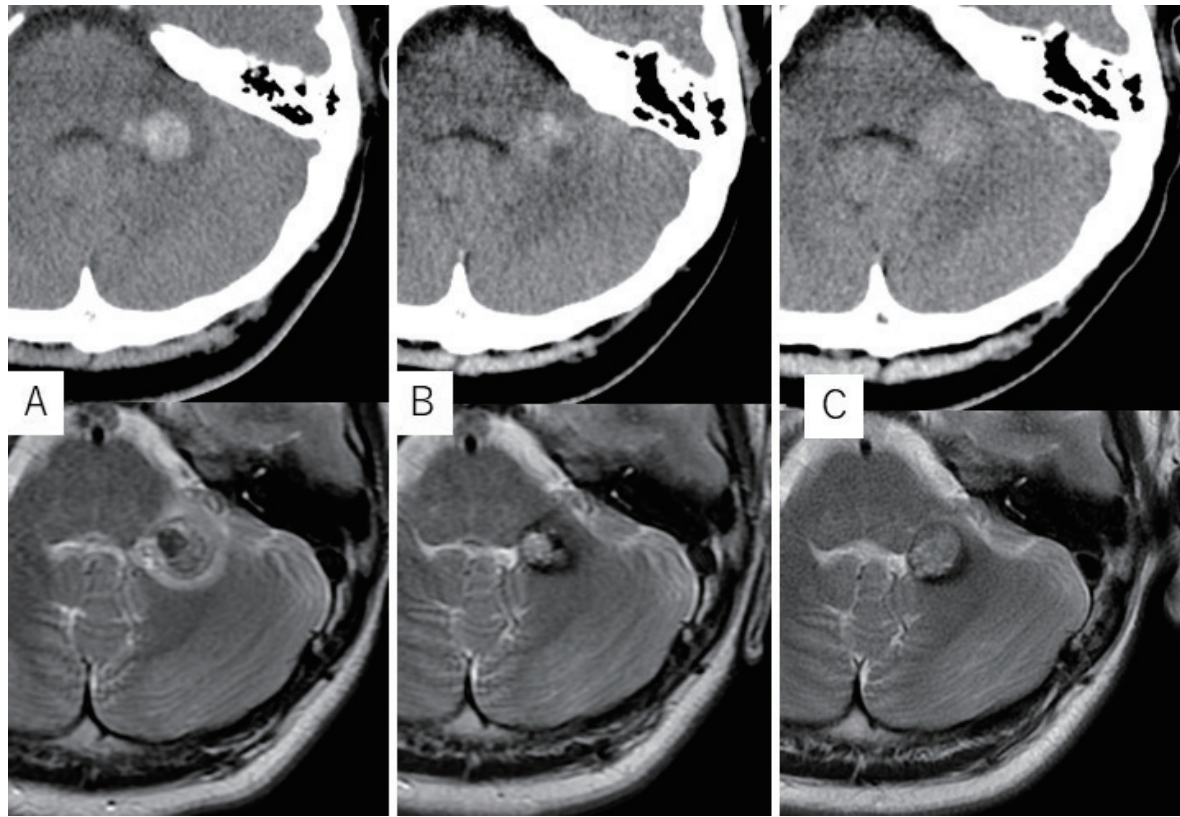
Computed tomography (CT) at onset shows a high-density round mass lesion with perifocal edema in the left cerebellar peduncle, the core of which was hypointense on magnetic resonance imaging (MRI) (A). Follow-up CT and MRI, 1 year after onset (B) and 2 years after onset (C), showing enlargement of the lesion and surrounding hypointense rim on MRI.
